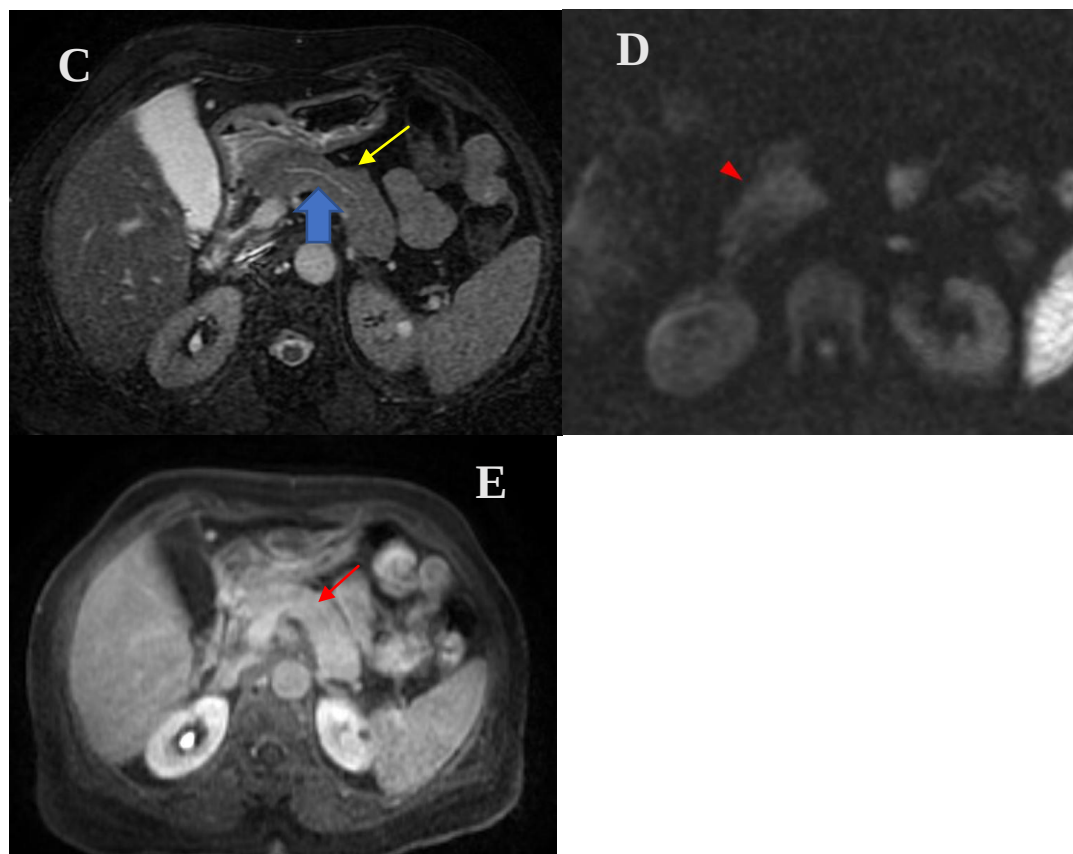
1D& 1E: A seventy-three-year-old female, presented with abdominal pain; Axial T2 W,DWI and post contrast axial T1 W MRI of the abdomen at the level of the pancreas shows sausage shaped bulky pancreas (yellow arrow) with diffusion restriction on DWI arrow head) showing heterogenous enhancement with few patchy areas of persistent enhancement (red arrow) predominantly in the tail of pancreas. There is mild irregularity of the pancreatic duct blue arrow) in the body and tail region of pancreas.
